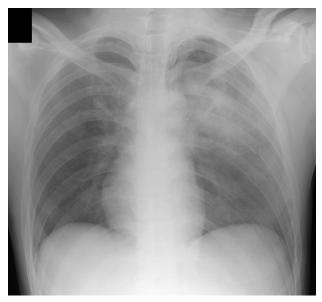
Plain chest roentgenogram obtained in the supine position upon arrival. Left pneumothorax and mild deviation of the mediastinal shadow toward the right side are seen. The left upper lobe is mildly collapsed, and an intralobar small macular infiltrative shadow is seen. The left thoracic cavity is of generally decreased radiolucency. There are fractures in the left sixth and seventh ribs and subcutaneous emphysema on the left side.
